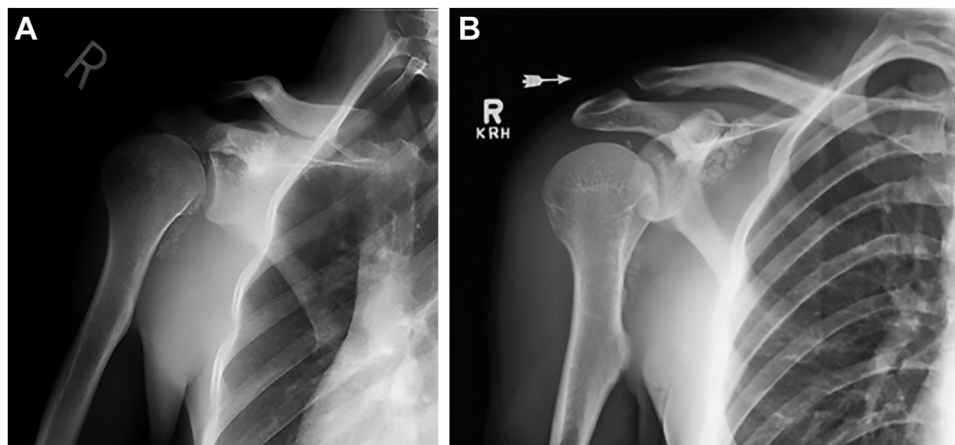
(A) Preoperative true AP X-ray of the right shoulder demonstrating loose bodies inferior to the humeral head. (B) Preoperative AP X-ray of the right shoulder demonstrating loose bodies medial to coracoid. AP, anteroposterior.
